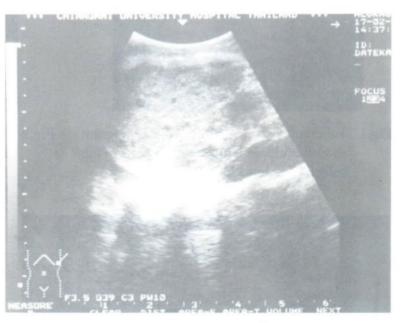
Nocardiosis. Sagittal ultrasonogram shows multiple hypoechoic lesions in the spleen.
